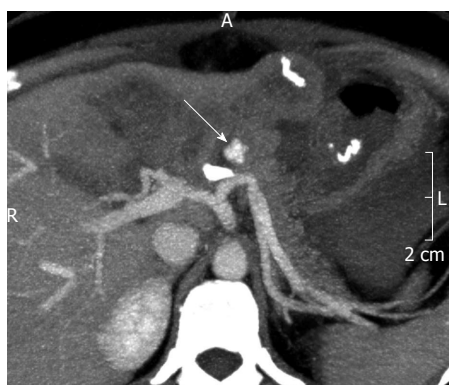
Unenhanced computed tomography showing contrast media extravasation anterior to the splenic artery^[61].
